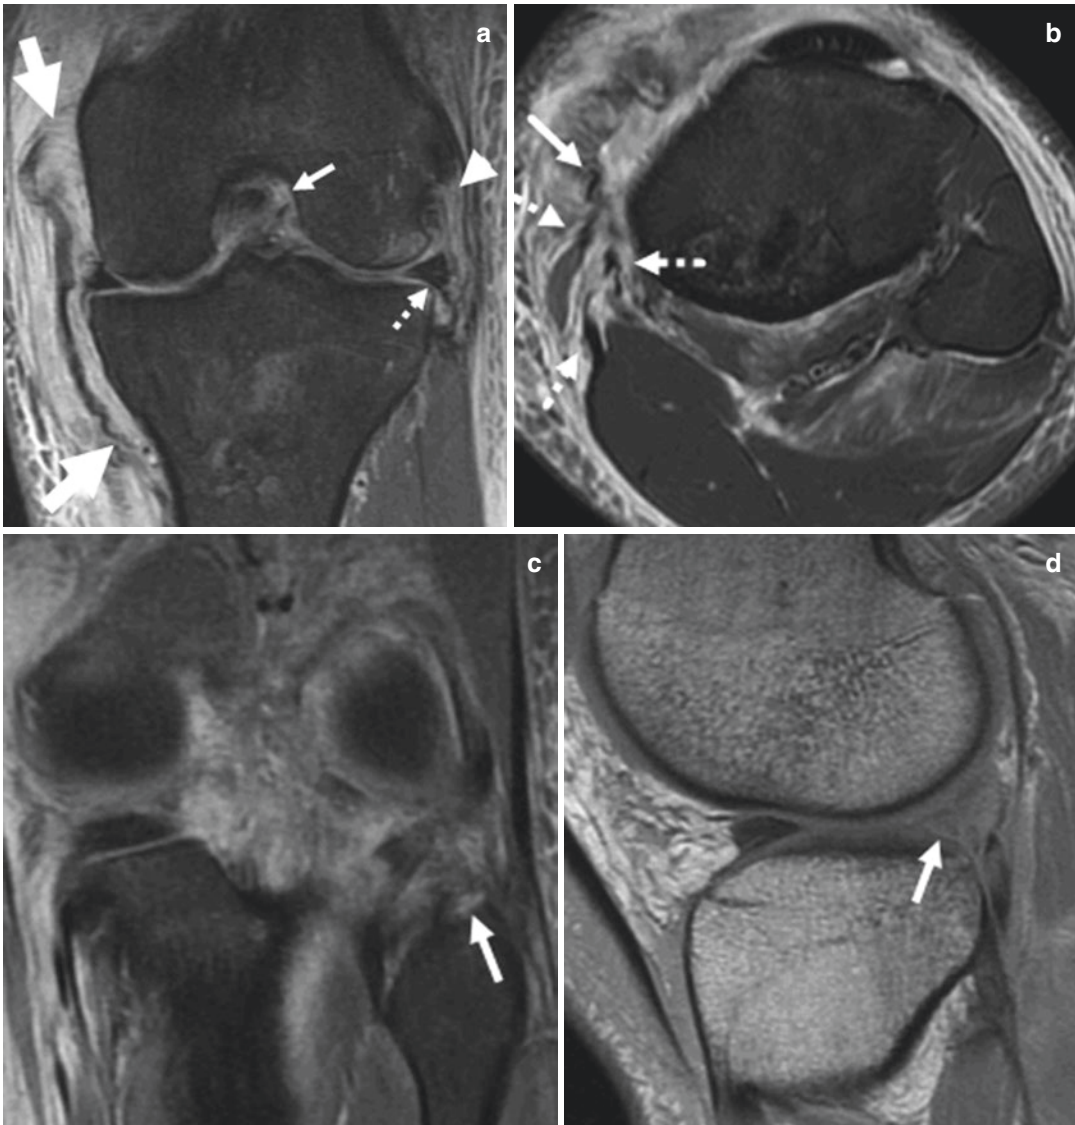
(a) Coronal T2-weighted fat-suppressed image from a 17-year-old boy demonstrates complete ACL tear (*arrow*) as well as complete proximal and distal tears of the superficial medial collateral ligament (MCL) (*thick arrows*). The proximal retraction and wavy appearance of the distal MCL are associated with a Stener-like lesion. There is also a high-grade tear of the fibular collateral ligament (*arrowhead*) and abnormal extrusion of the lateral meniscus (*dashed arrow*). (b) An axial T2-weighted
